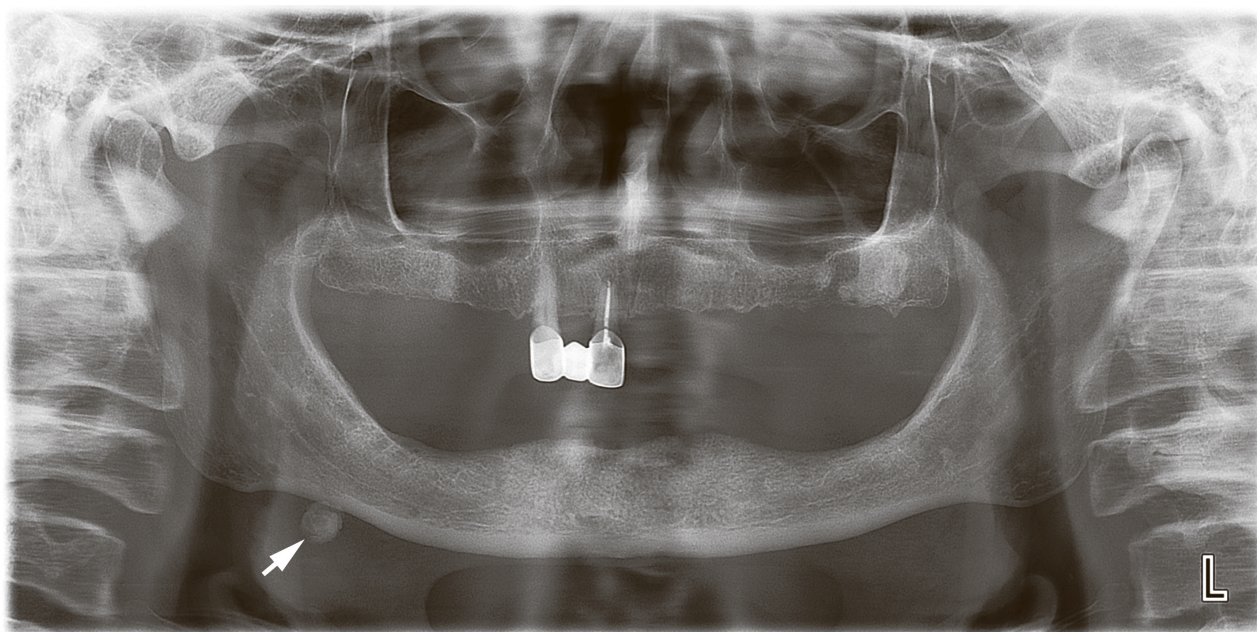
Case 1: An orthopantomogram of a 66-year-old gentleman with symptoms of obstructive submandibular sialadenitis. A radiopaque causative sialolith with laminated structure is indicated by *arrow*.
